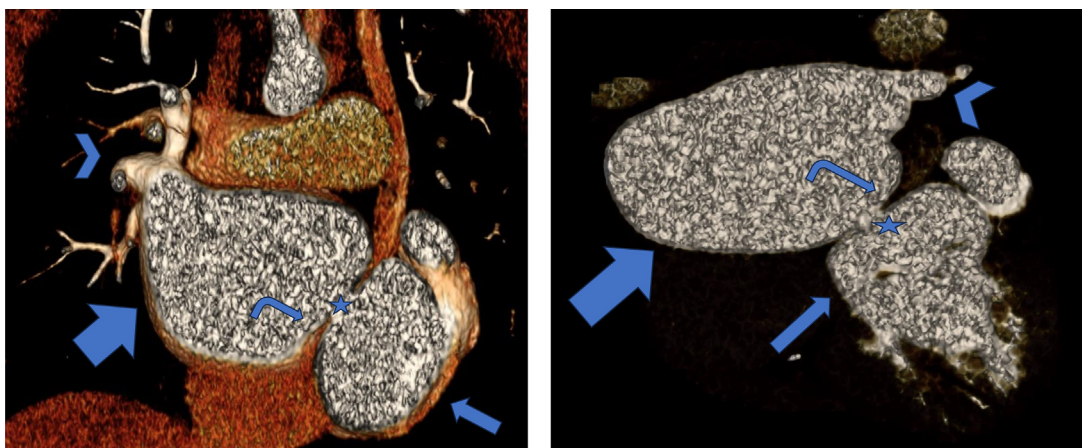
Two images of 3D reconstruction cardiac CT scans, show a fibromuscular membrane (curved arrow), with internal fenestration (star), dividing the left atrium into 2 chambers, a proximal chamber (thick arrow) containing the pulmonary veins (arrowhead), and a distal chamber “true” left atrium (thin arrow) containing the left atrial appendage.
